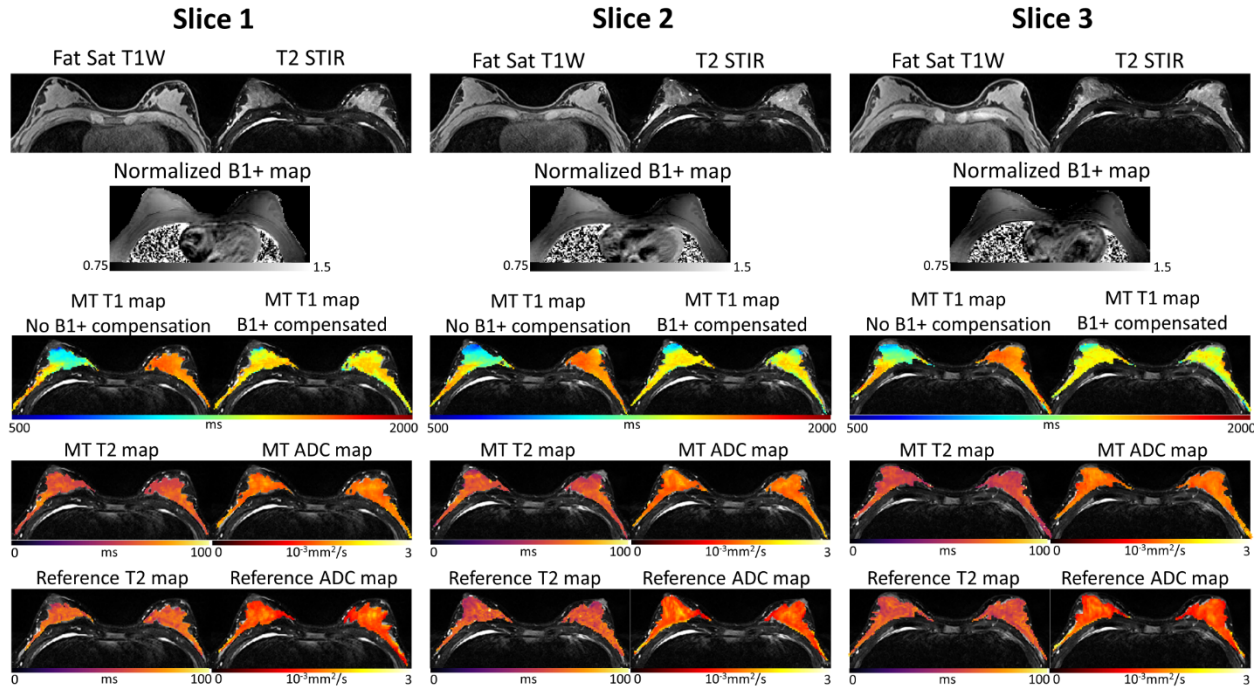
In vivo demonstration on a healthy volunteer for simultaneous T1/T2/ADC mapping of three slices. For each slice, the first row shows the clinically adopted fat saturated T1-weighted image and STIR image. The second row shows the separately acquired B1+ map (normalized with the prescribed 5° flip angle) which demonstrates the nonuniform B1+ field across the FOV. The third and fourth rows show the T1/T2/ADC maps generated from the Multitasking framework, where specifically, the third row shows the fitted T1 maps without and with B1+ compensation. Uniform T1 maps are produced with B1+ compensation, while substantial T1 variation is present without B1+ compensation. The T2/ADC maps are the same with or without B1+ compensation, as the flip angle term only interact with T1. The fifth row shows the reference T2 and ADC maps. Multitasking T2/ADC maps are consistent with the reference T2/ADC maps.
